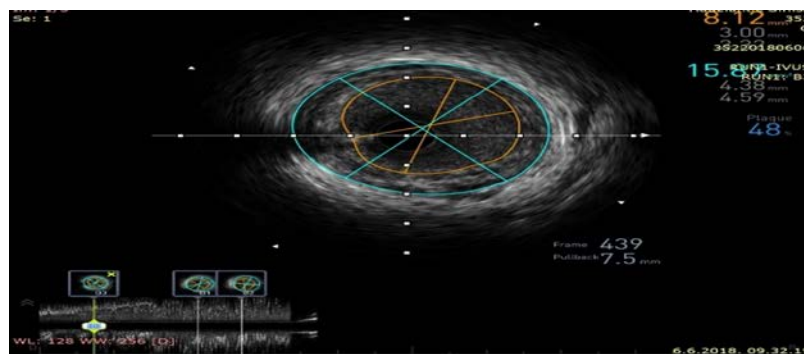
Intravascular ultrasound shows 48% stenosis in the left main stem coronary artery.
